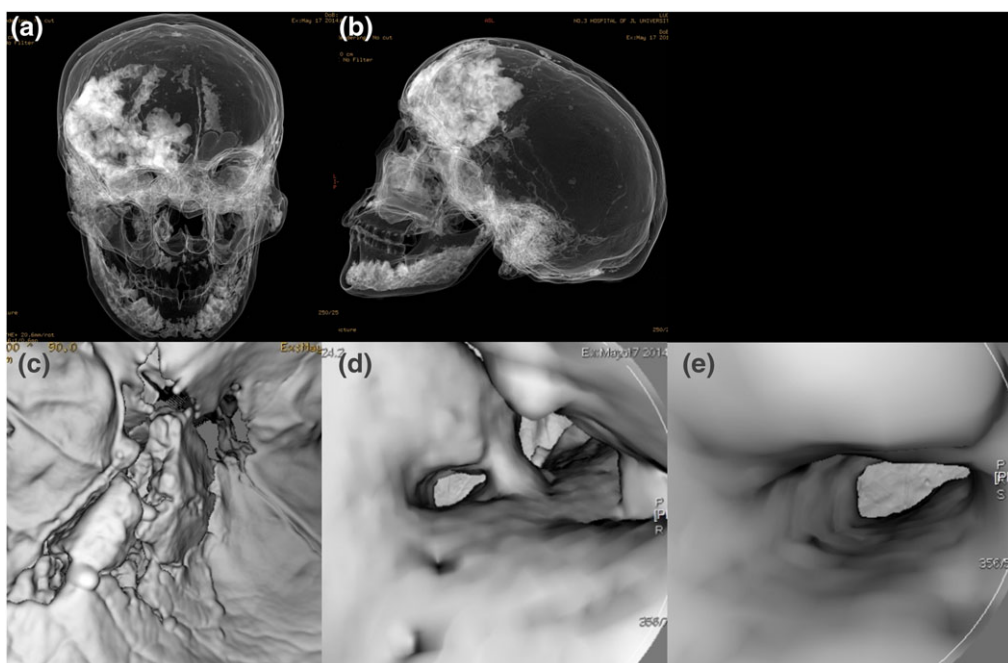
Tissue transition projection (TTP) images (a, b) and CT virtual endoscopy (CTVE) (c–e): (a) the right frontal sinus was pressured and was not displayed clearly; (b) the cavity of the left frontal sinus, which shifted to the left with the sagittal suture, was shown clearly; (c) in the bones of the lesion area, irregular sutures have formed in the lesion; (d) the entrance to the right optic nerve canal; (e) the wall of the right optic nerve canal. [Colour figure can be viewed at wileyonlinelibrary.com]
